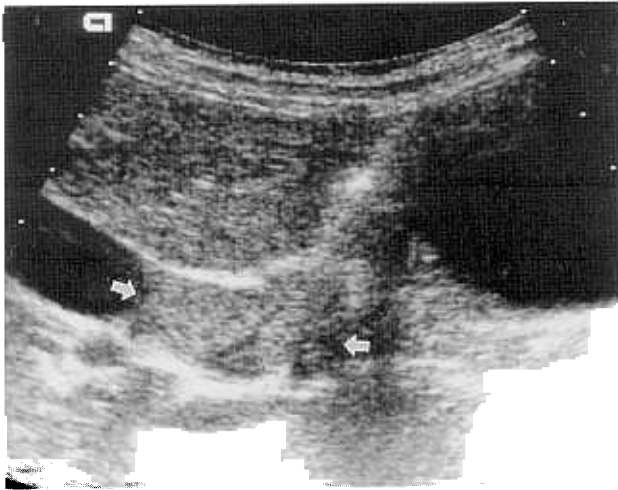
Abdominal ultrasonography showing a soft tissue mass (arrows) from the confluence of the main right and left bile ducts to the common hepatic duct.
